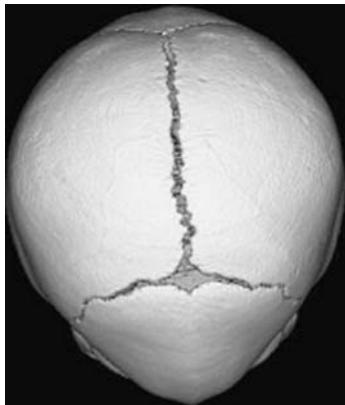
Preoperative 3D CT of the skull at 6 months showing the closed metopic suture. The patency of the coronal, sagittal, and lambdoid sutures is shown. Superior view
